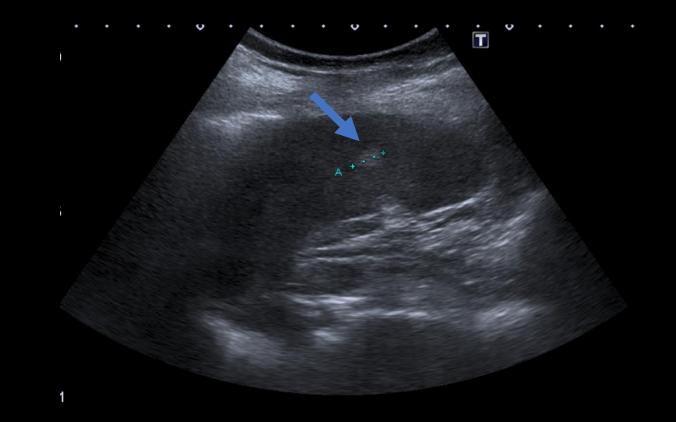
Ultrasound. Focal hyperechoic nodule, a feature less common than hypoechoic spleen lesions.
